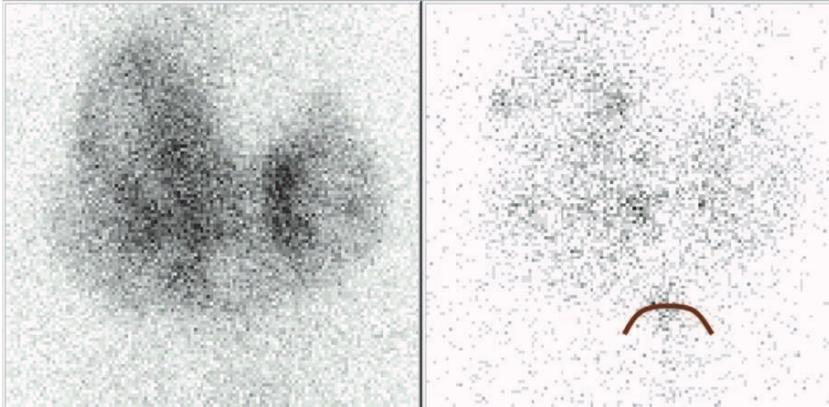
Thyroid scintigraphy - nodular goiter with normal function and mechanical syndrome
